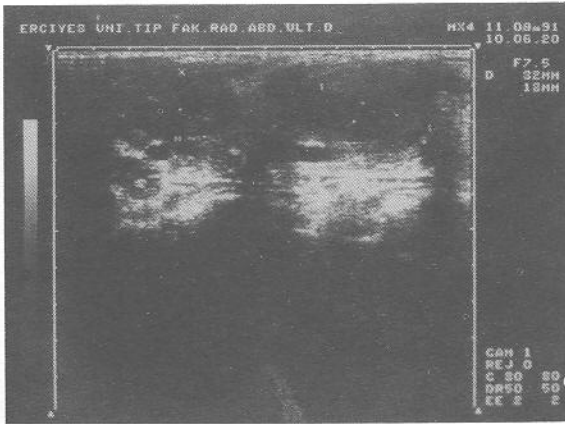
Ultrasound examination of the patient showing a cyst in the right thyroid lobe.
